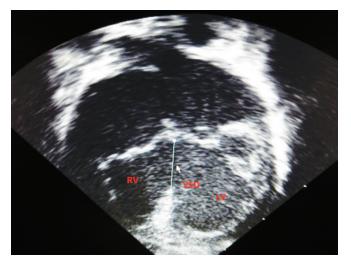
Upper chamber view of the heart on 2D echocardiography
